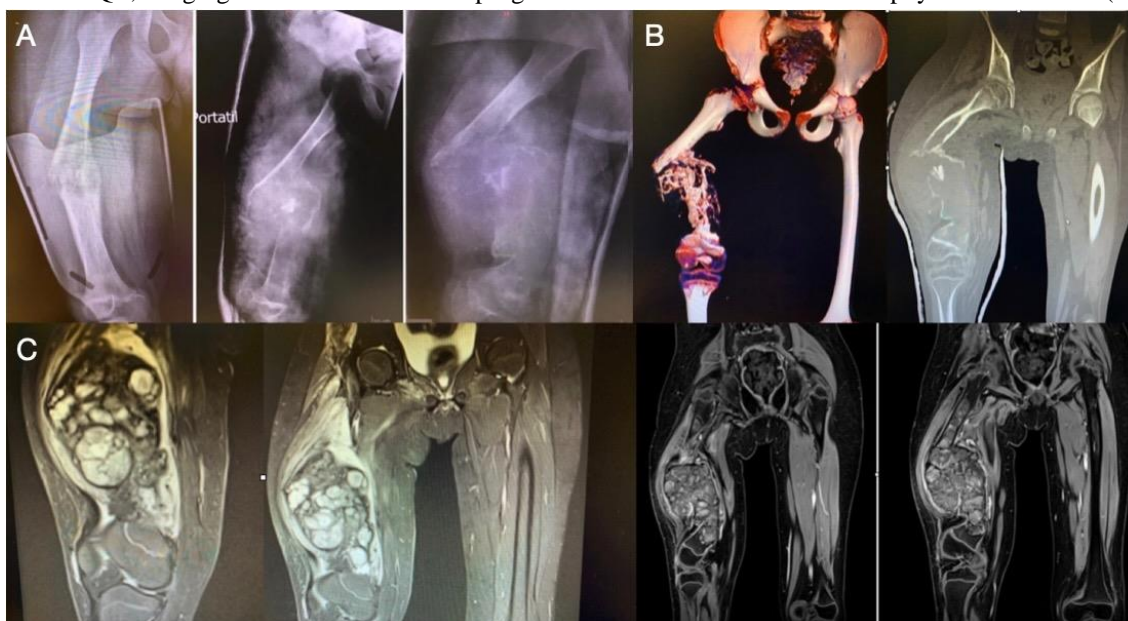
imaging controls after neoadjuvant chemotherapy. Initial Rx. A Rx at 8 weeks and 12 weeks. B Coronal CT and 3D reconstruction. C MRI. In all of them, an increase in bone injury and soft tissue mass is observed.
